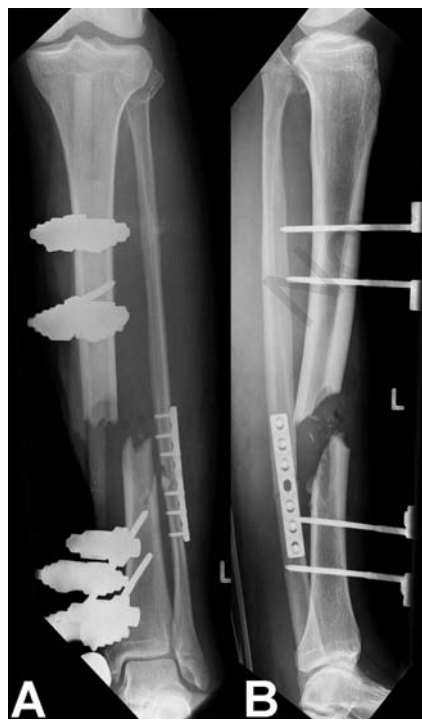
X-rays (anterior (A) and lateral view (B)) of Patient 7 at the day of admission with central bone defect after an open fracture of the tibia (Gustilo type III B).
